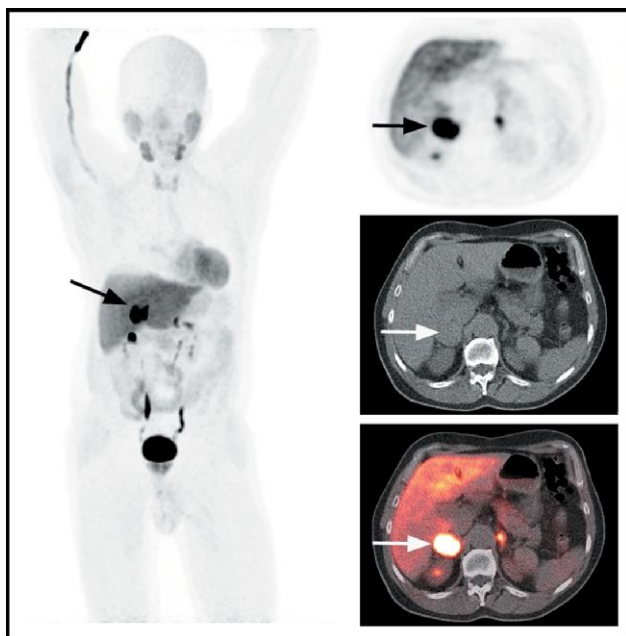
A 61-year-old man (patient 8) presented with a right adrenal mass and elevated metanephrine levels. Positron emission tomography (PET) imaging at 90 minutes following intravenous injection of 445 MBq (12.3 mCi) of 3-[¹⁸F]fluoro-*para*-hydroxyphenethylguanidine (3-[¹⁸F]pHPG). Left: Maximum intensity projection (MIP) imaging of the 3-[¹⁸F]pHPG scan shows uptake in a right adrenal mass (arrow) with a standardized uptake value (SUV_{max}) of 24.1. 3-[¹⁸F]pHPG activity is also seen in the parotid glands, thyroid, heart, liver, and left adrenal, with genitourinary excretion of radiotracer in the kidneys and bladder. Right: Axial slices PET (top), computed tomography (CT) (middle), and PET/CT (bottom) show intense 3-[¹⁸F]pHPG activity in the right pheochromocytoma (arrows).
